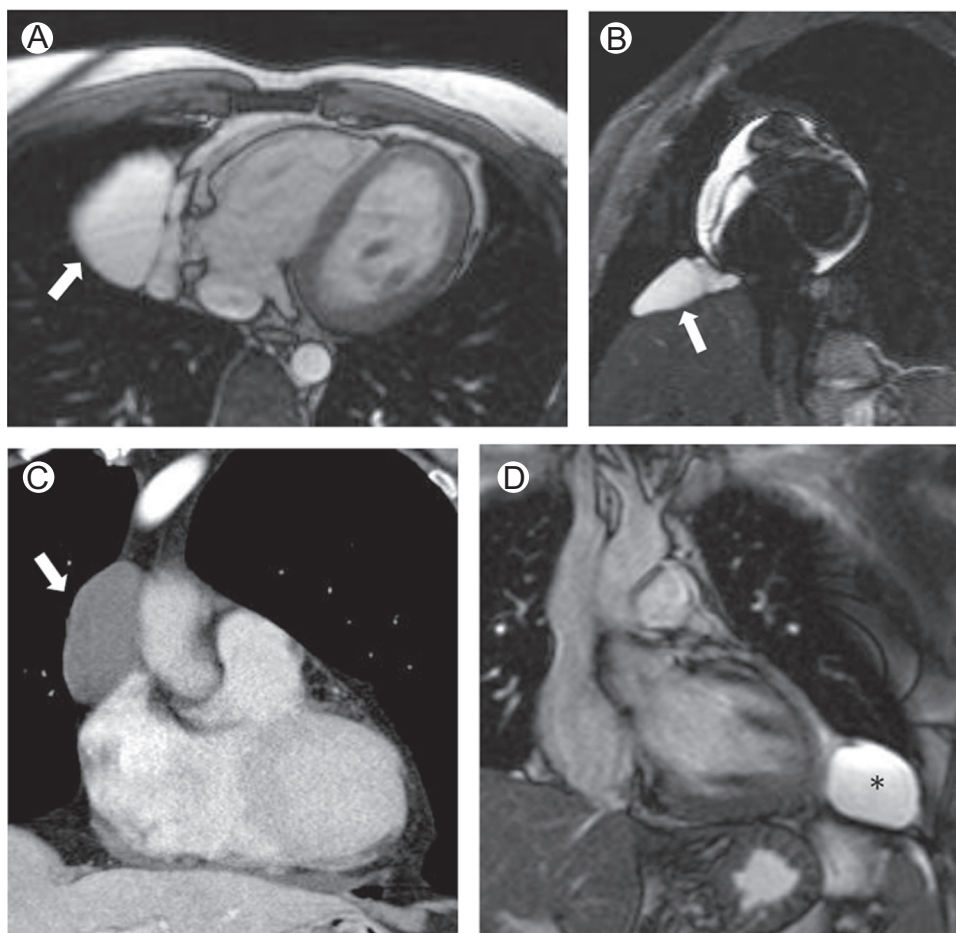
Pericardial cysts in 3 different patients. Axial balanced steady-state free precession (bSSFP) (A) and short-axis T2-weighted image (B) showing a well-circumscribed, T2 hyperintense, thin-walled lesion in the right cardiophrenic angle (arrows). Coronal contrast-enhanced CT image of the chest (C) in a different patient shows a smooth-contoured fluid-attenuation lesion in a slightly higher location adjacent to the ascending portion of the ascending aorta (arrow). Coronal bSSFP image of the chest (D) in a third patient shows a well-defined T2 hyperintense mass (asterisk) in the left cardiophrenic angle. (Case courtesy Santiago Martinez, MD.)
